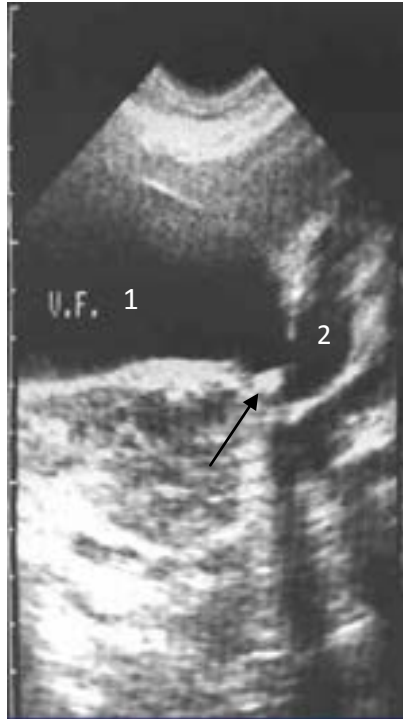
Ultrasound of gallbladder. Increased gallbladder (1) and choledochus (2). In the field of a neck of a gallbladder stone (arrow), giving an acoustic shadow
